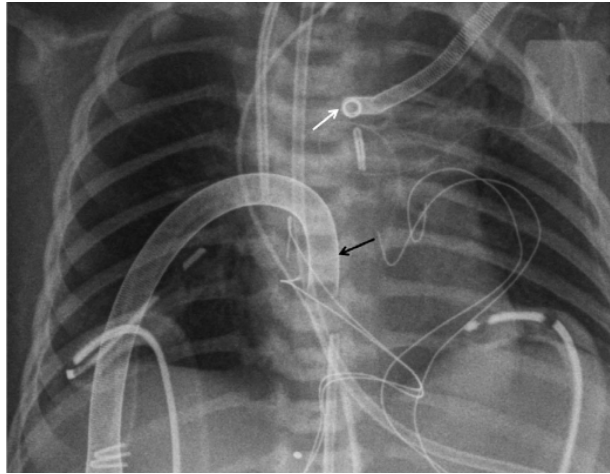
Chest radiograph of a pediatric patient on VA-ECMO utilizing central placement. The white arrow points to the blood return location through the subclavian artery and the black arrow points to the blood disposal location through the superior vena cava [13].
